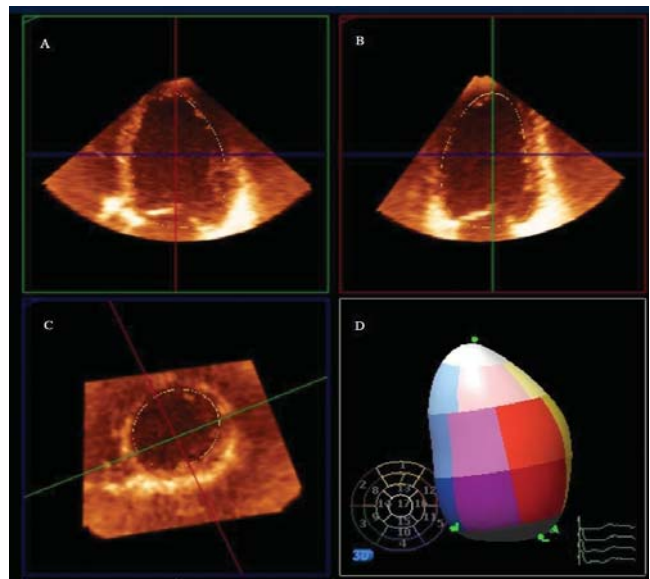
Real time 3-dimensional echocardiography demonstrating LV contour tracing in the two apical and parasternal short axis views (panels A-C). Panel D demonstrates the 3D LV volume and the bottom panel demonstrates graphically, LV volume change over the cardiac cycle.
